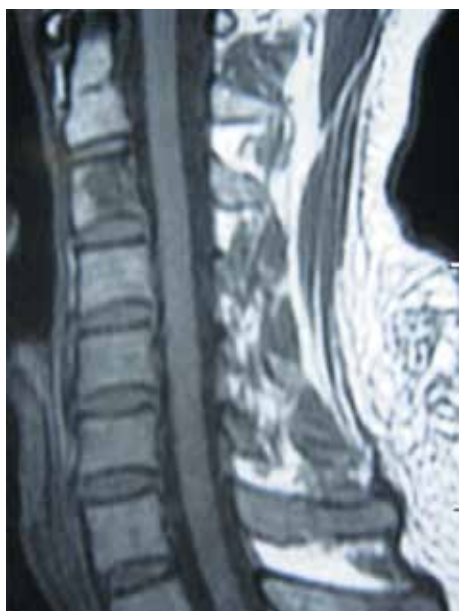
T1-weighted sagittal MRI image of 43-year-old man with neck and left shoulder pain revealed low signals at the C3 vertebral body.
